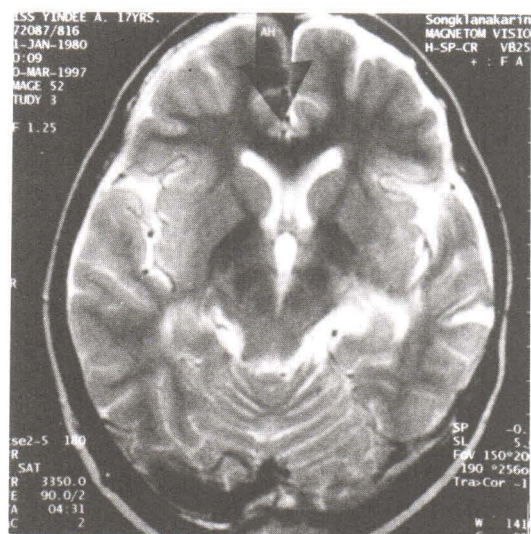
A brain MRI on March 1997 : showing no evidence of tumor recurrence.
